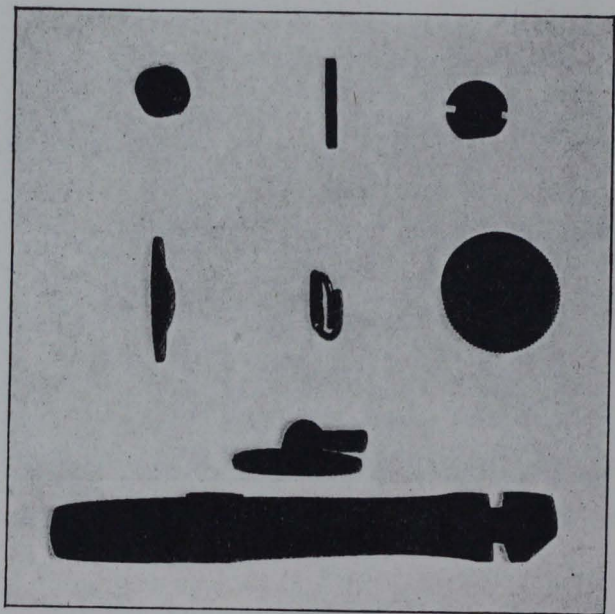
RADIOGRAM OF OBJECTS WITH X-RAY TUBE DIRECTLY OVER CENTRE OF PLATE.
